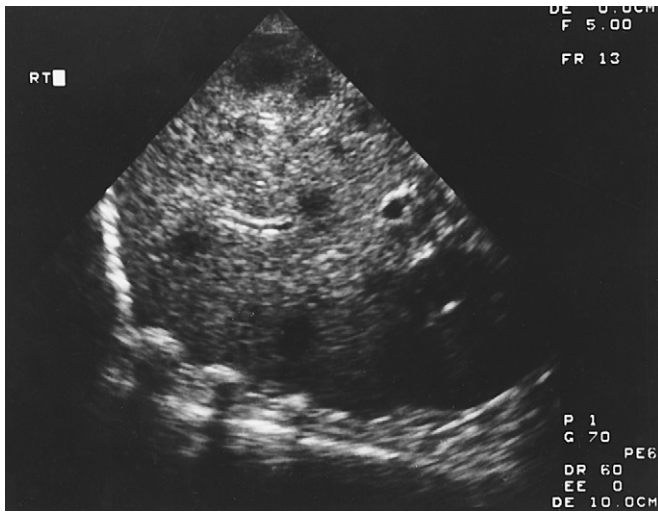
Sonogram demonstrating several hepatic abscesses (echolucent areas) in the same patient as in Figure 107-13.
